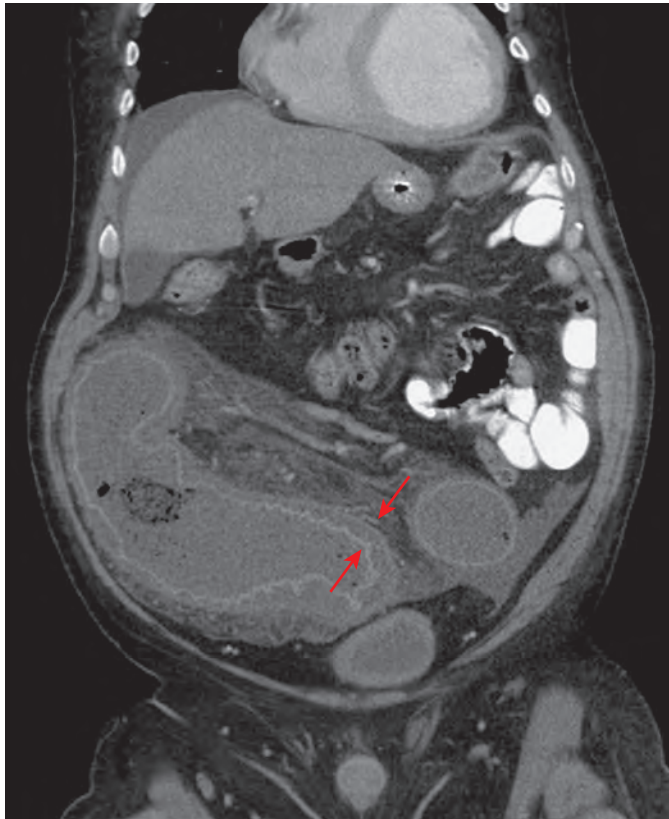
Pseudomembranous colitis: CT findings. Coronal reformatted CT image shows marked mural thickening with submucosal edema (arrows) of a redundant sigmoid colon. Note the ascites and inflammatory change in the adjacent sigmoid mesocolon.
